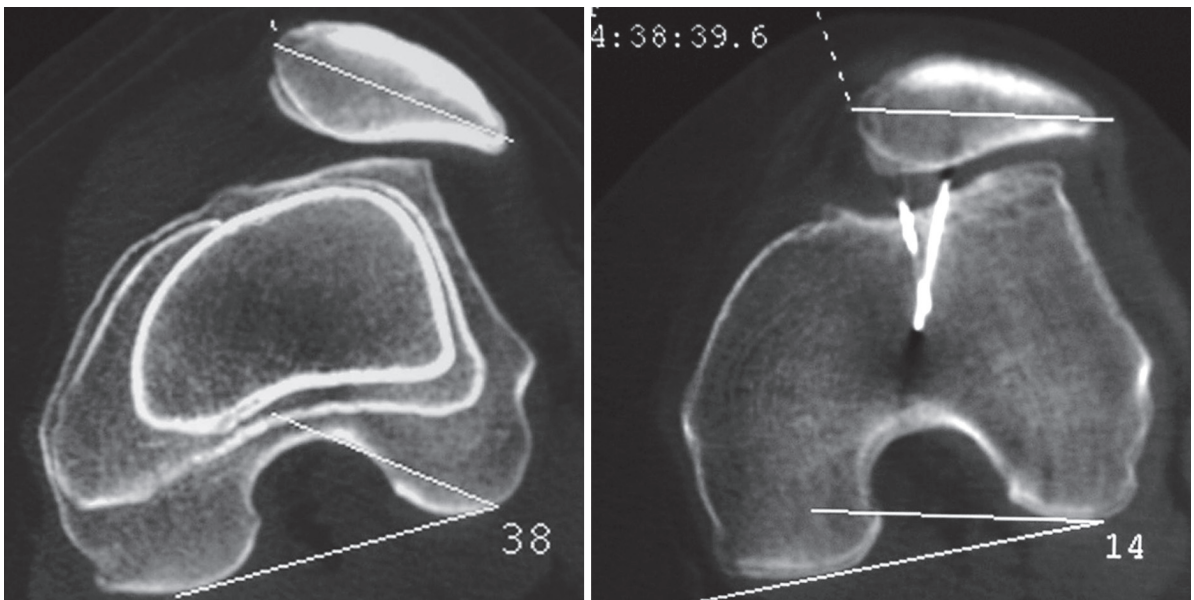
CT scan axial views before and after trochleoplasty. The trochlear sulcus is restored and patellar tilt is corrected. Patellar subluxation is also improved
